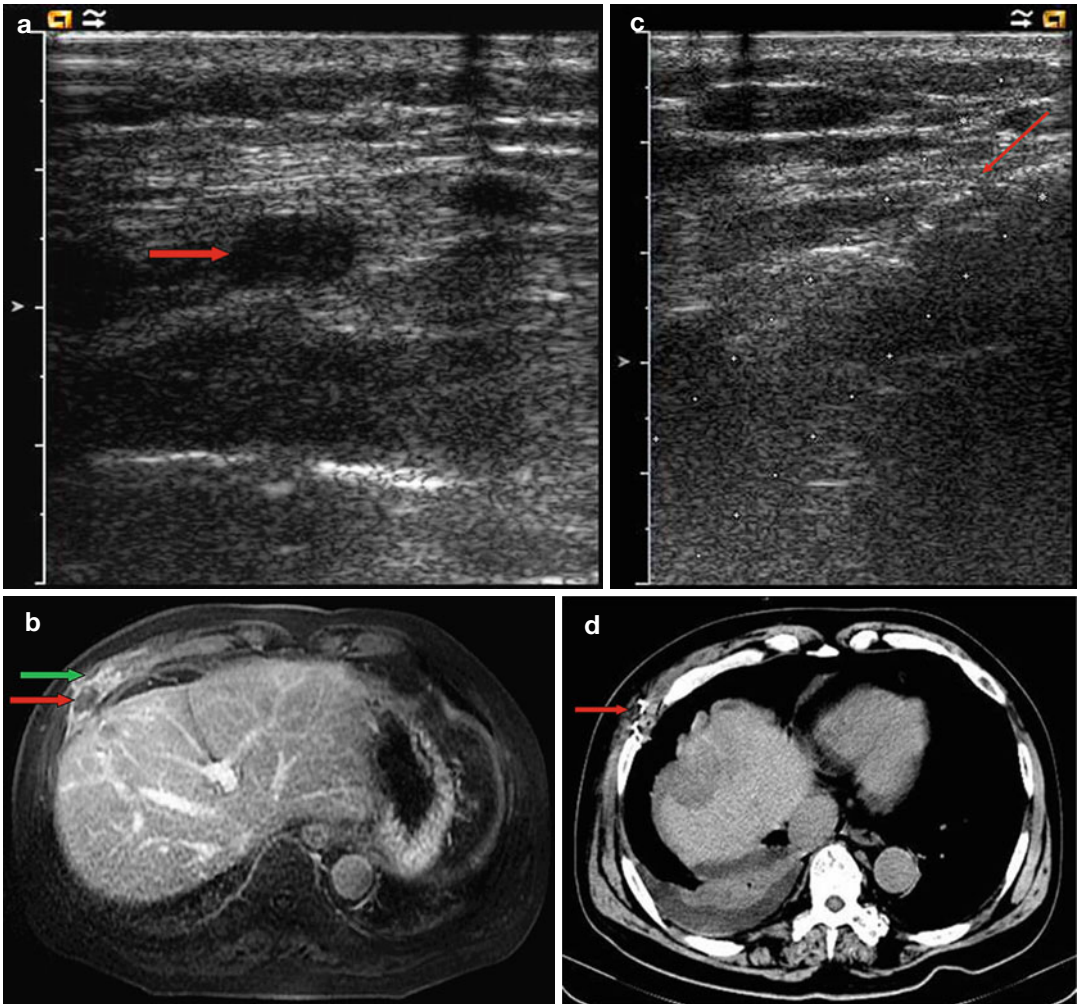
Iodine-125 seed implantation combined with MWA for a 62-year-old man with right chest wall metastatic tumor. (a) Conventional ultrasound scan shows a hypoechoic lesion (arrow) with the size of 2.3×1.6 cm. (b) Pretreatment MRI scan shows the chest wall lesion still alive after MWA
